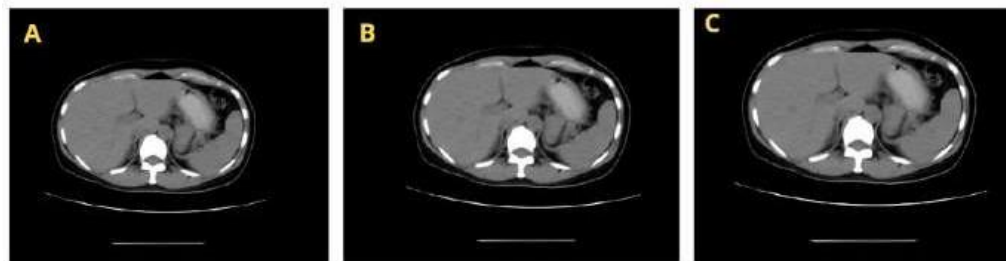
Abdomen CT scan with clinical intra-abdomen tumor (A); Using 60% ASiR-V value variation; (B) Using 70% ASiR-V value variation; (C) Using 80% ASiR-V value variation
